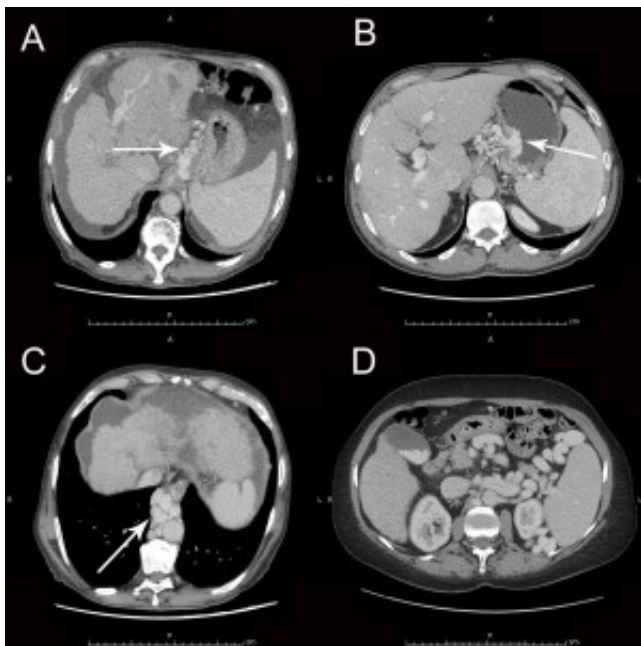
CT axial images in liver cirrhosis. A) The left gastric vein is enlarged, with multiple collaterals (arrow); thrombosis of the left branch of the portal vein; a hepatocellular carcinoma in the left lobe. B) A dilated left gastric vein with multiple collaterals is connected with gastric fundic varices (arrow).C) Big esophageal and peri-esophageal varices in the lower posterior mediastinum, liver atrophy with ascites. D) Portal hypertension secondary with splenomegaly, multiple perisplenic collaterals and cholelithiasis.
